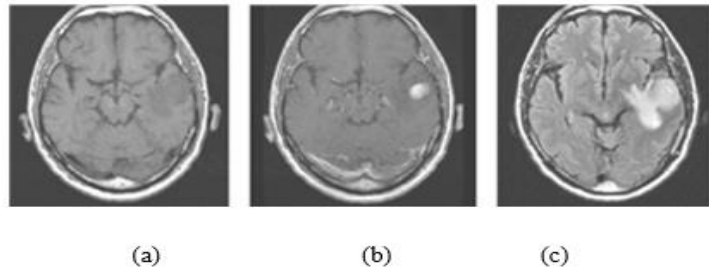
A tumour with edema and complete enhancement. a) An axial slice of the T1-weight brain image b) An identical slice of the T1-weight brain image enhanced by contrast. c) The FLAIR picture
